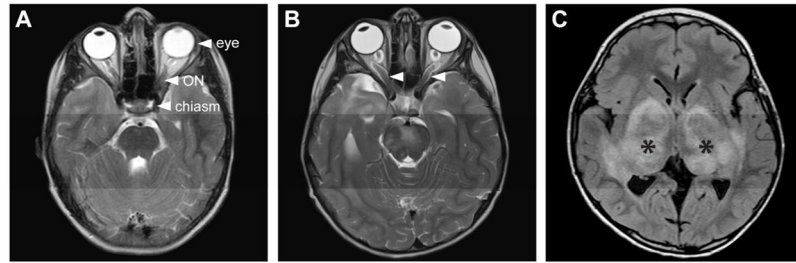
Location and MRI characteristics of NF1-optic pathway gliomas (OPGs)
